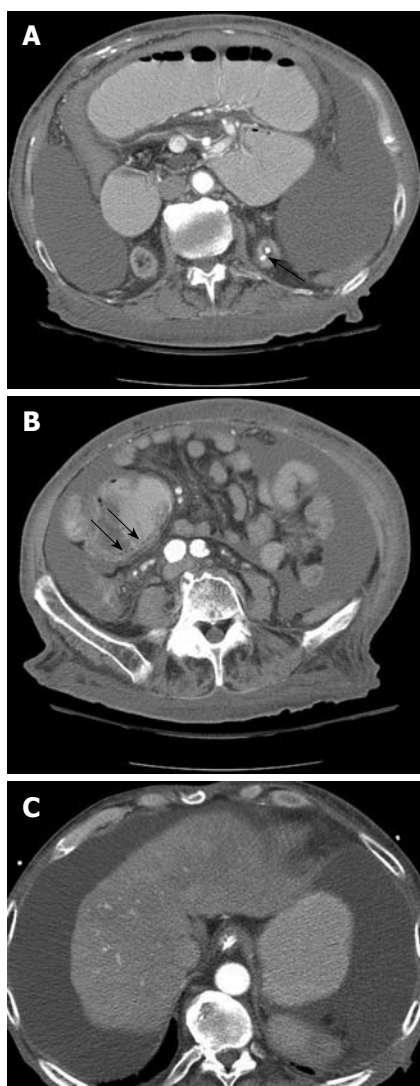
CT scan of the abdomen. showing stones in the left kidney (A, arrow), pneumatosis intestinalis (B, arrow) and shrunken nodular liver with abdominal ascites (C).
